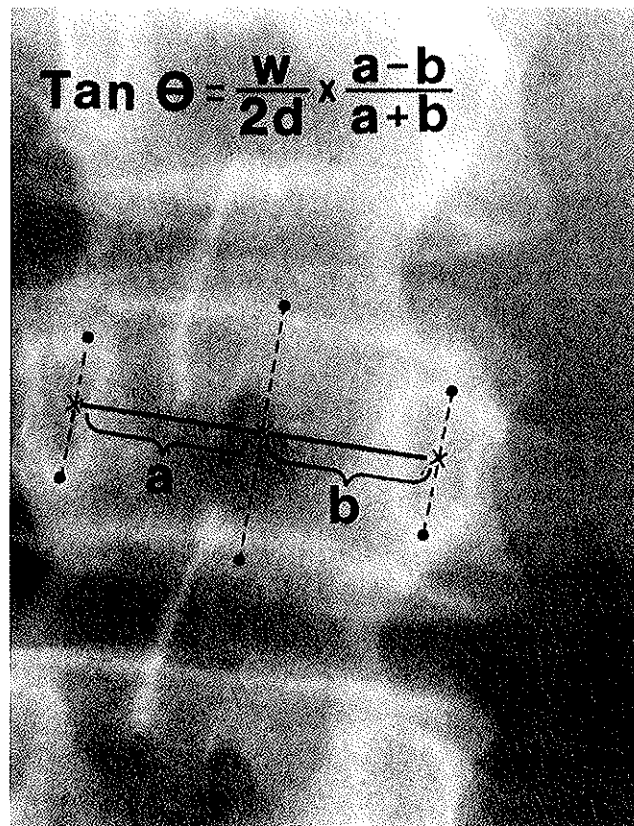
Method of measurement of axial rotation of vertebrae from a single PA film by the pedicle offset method. Because the ratio of measurements is used, the measure is independent of radiographic magnification. The method relies on the width-to-depth ratio. Experimentally determined values are given in Table 1.
